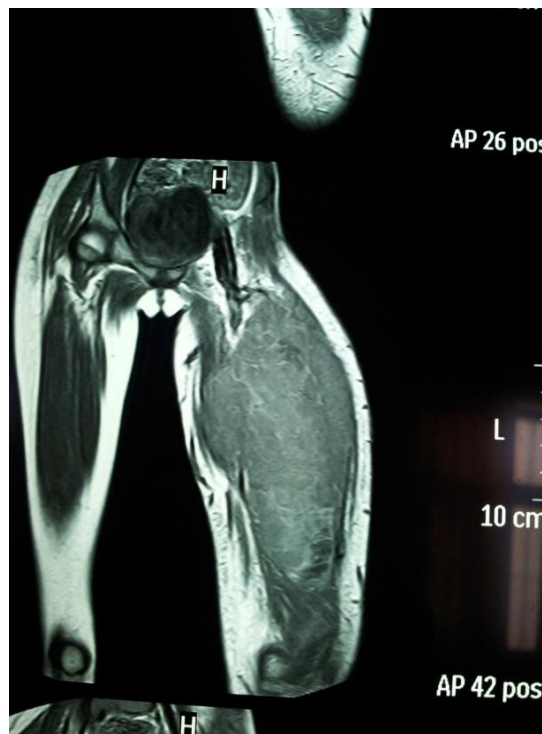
MRI SHOWING AN ENHANCED HETEROGENEOUS MASS AT SHAFT OF THE FEMUR WITH SOFT TISSUE EXTENSION OCCUPYING ANTERO- MEDIAL AND LATERAL COMPARTMENT.
